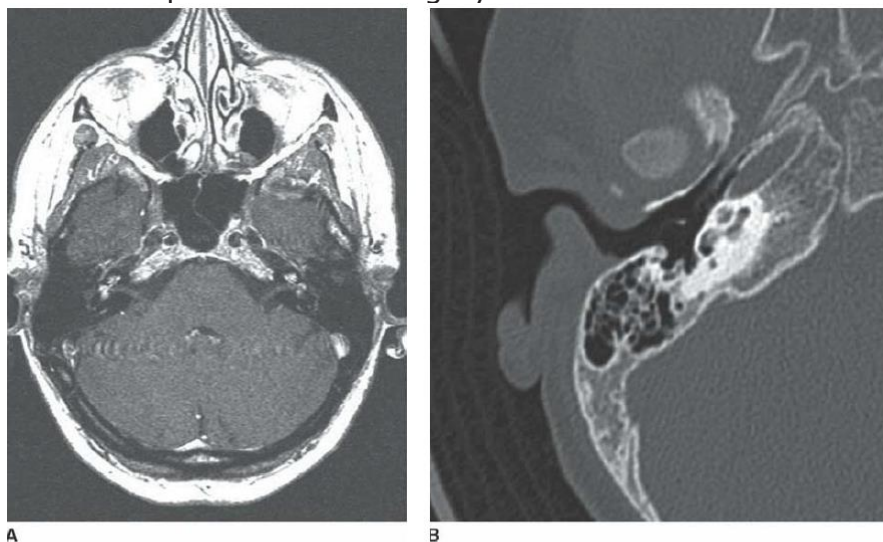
Labyrinthine obstruction. A: Axial-enhanced T1-weighted MRI demonstrates bilateral labyrinthine enhancement. B: Axial bone-window CT demonstrates postmeningitic ossification within the basal cochlear turn.
